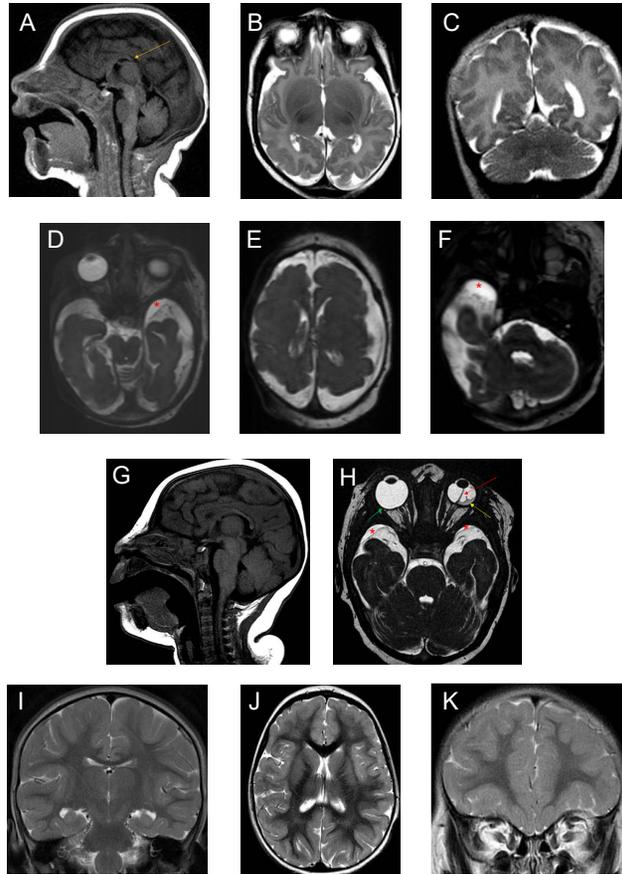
Neuroradiological findings in four patients with *KIF11* variants. Select images from magnetic resonance imaging studies are shown. Sagittal images shown are T1-weighted and axial and coronal images are T2-weighted. Patient 1 (A, B, C) demonstrated microcephaly (A), hypoplastic splenium of the corpus callosum (A, orange arrow), and parietal and occipital lobe polymicrogyria (B,C). Patient 2 (D, E, F) was found to have microcephaly (D), a simplified gyral pattern (D, E), hypertrophied choroid plexi (E), and bilateral middle cranial fossa arachnoid cysts (D, F denoted by *). Patient 3 (G, H) had microcephaly and simplified gyral pattern (G) with right globe posterior staphylocoma (green arrow), left globe persistent hyperplastic primary vitreous (PHPV, red arrow), microphthalmia, retinal detachment (yellow arrow), and bilateral subdural collections (H, denoted by *). Patient 4 (I, J, K) had bilateral hippocampal malrotation (J) and abnormal gyral pattern with prominent sulci and smooth gyri (J,K).
